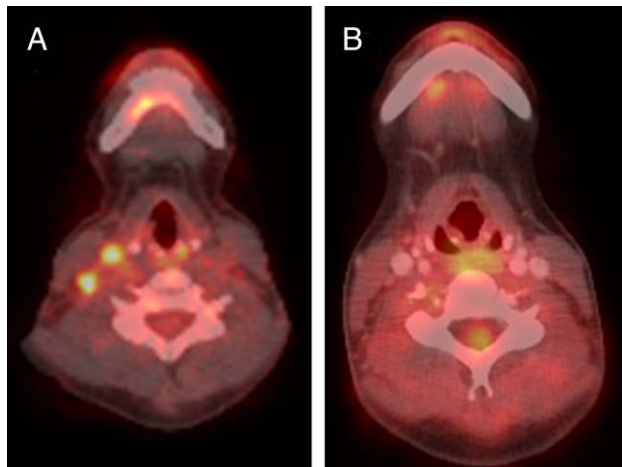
PET-CT of the neck showing hypermetabolic lymph nodes in the right neck (A), which resolved after chemotherapy (B). (Color plate 63.1)
